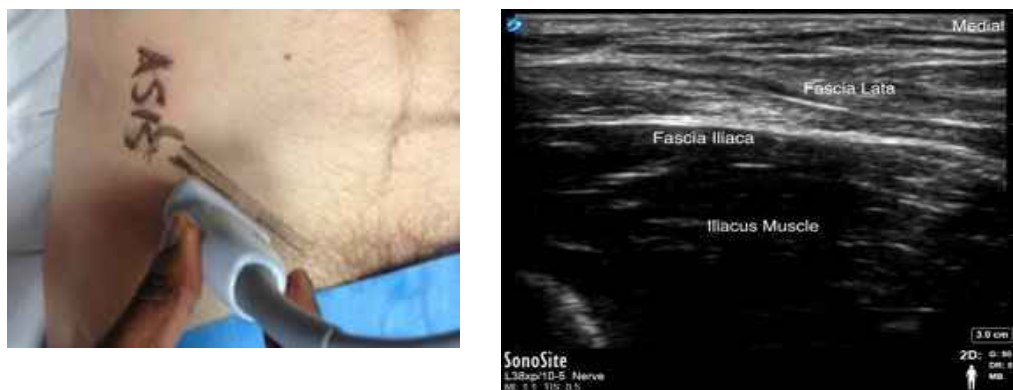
Ultrasound-guided femoral block
